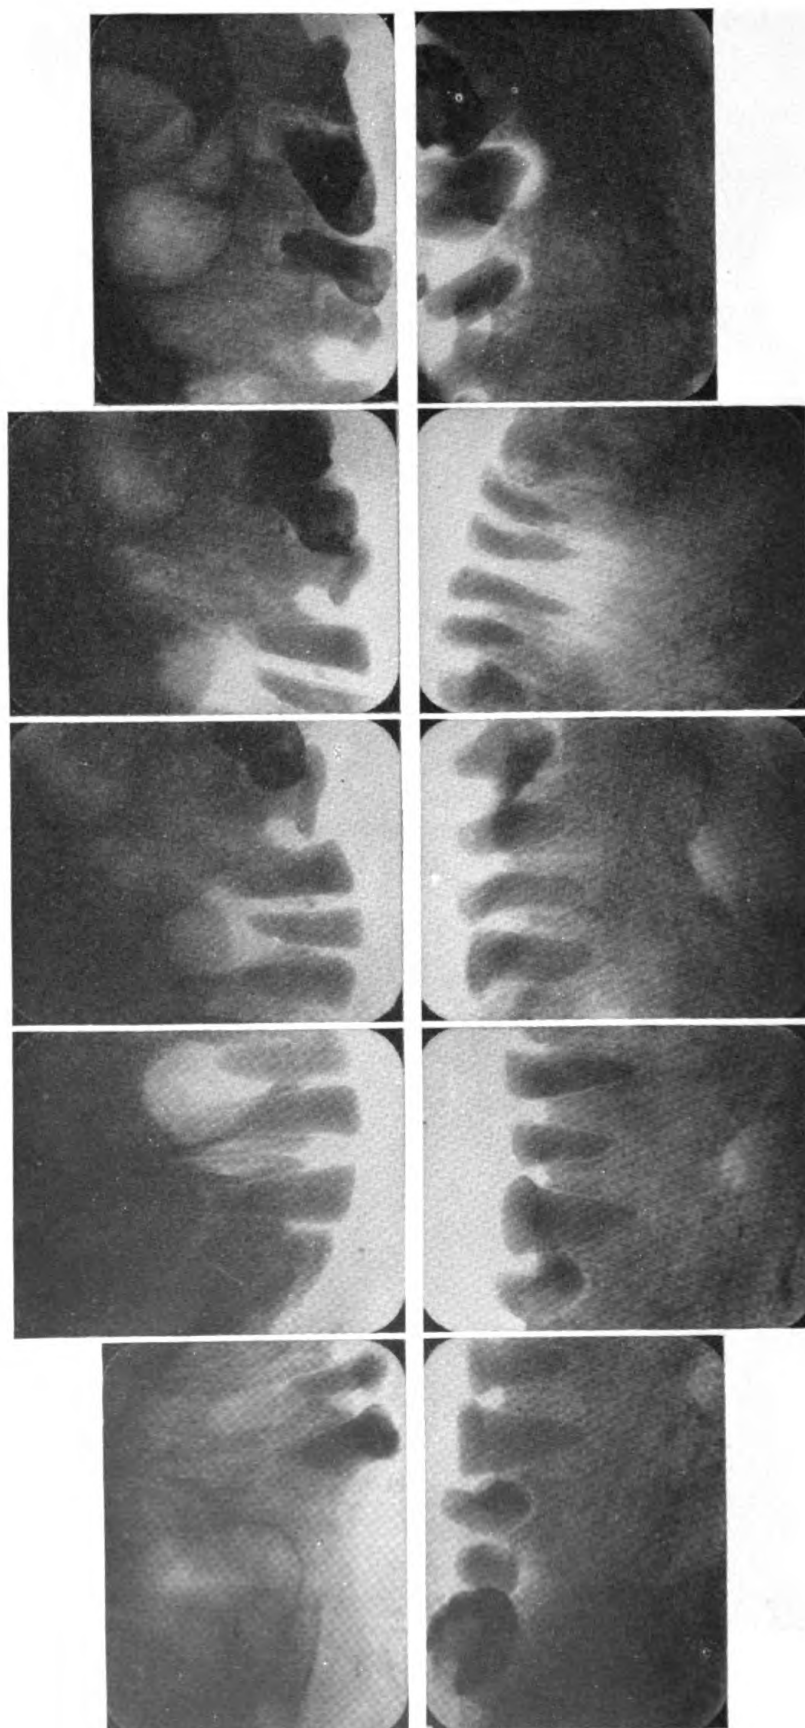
Radiographs of upper and lower teeth.
